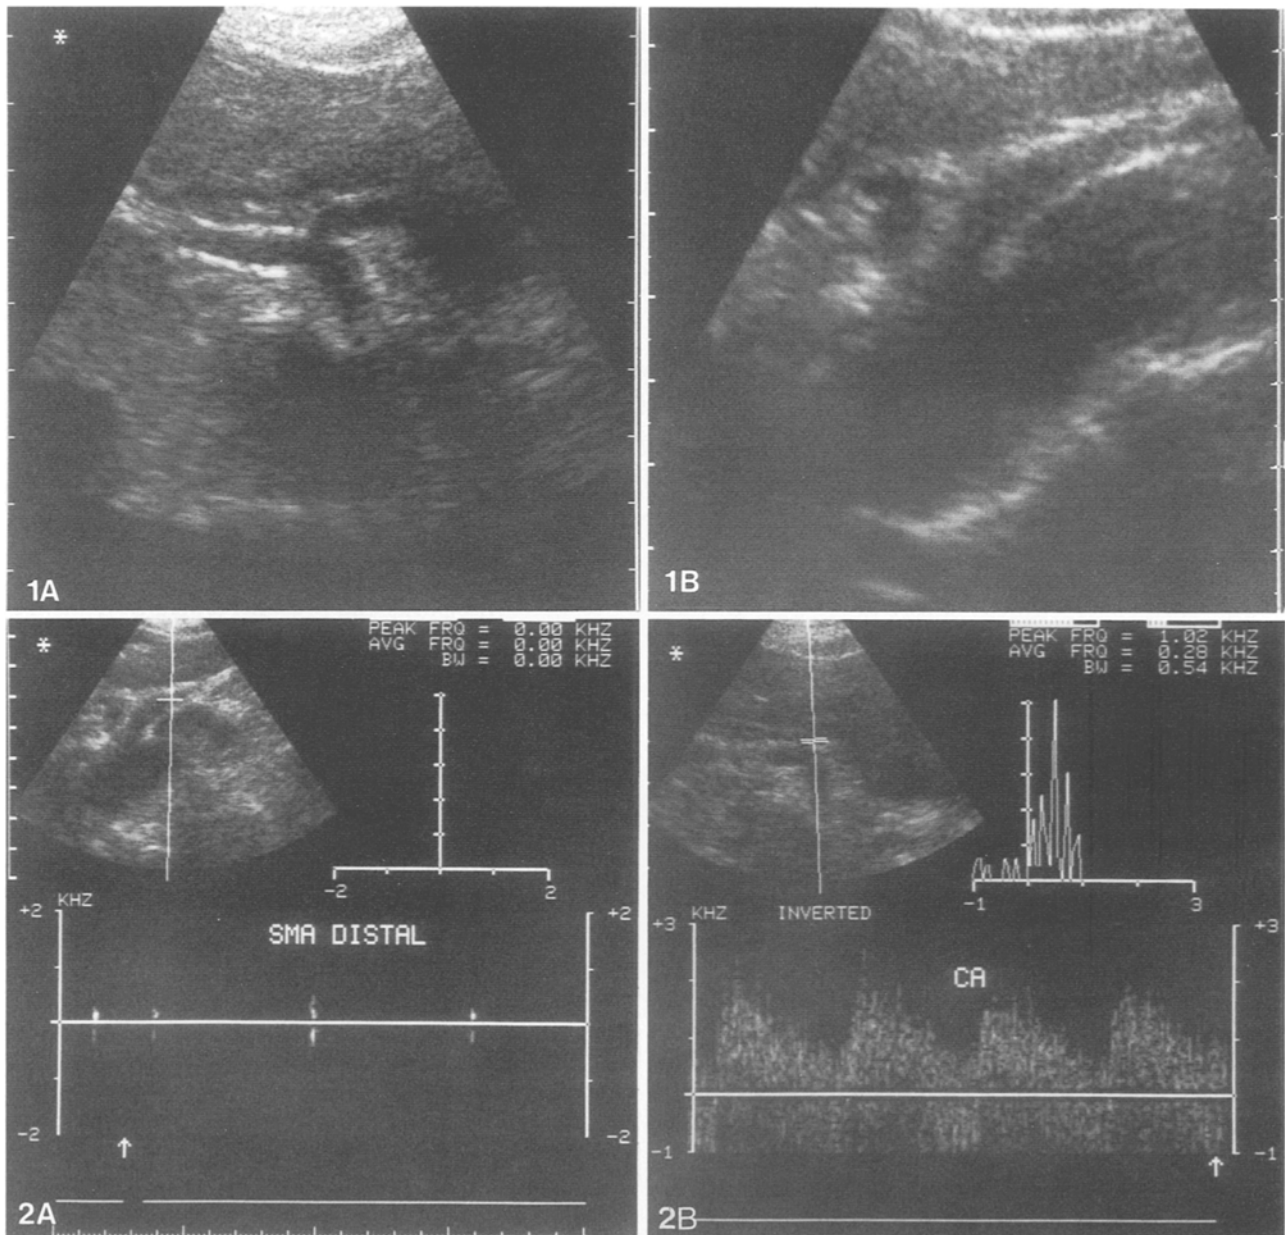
Case 1. A Transverse section ultrasound scan of stenosed origin of celiac artery. B Sagittal section ultrasound scan of apparently normal origin of SMA.
